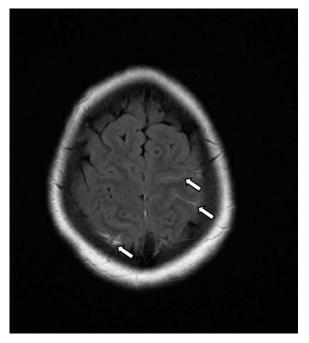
MRI brain FLAIR: subarachnoid hemorrhage noted in bilateral frontoparietal regions (arrows).
